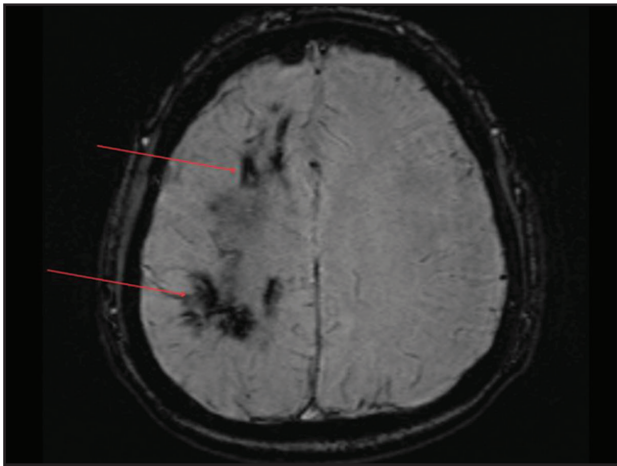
Susceptibility-weighted MRI (SWI) showing marked blooming artifacts corresponding to the heavily calcified lesions in the right frontal and parietal regions (red arrows).
